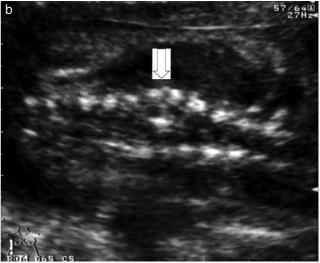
Case 5. Ultrasound images at 23 weeks' gestation showing an extra echogenic focus in axial (a) and coronal (b) sections (arrows).
